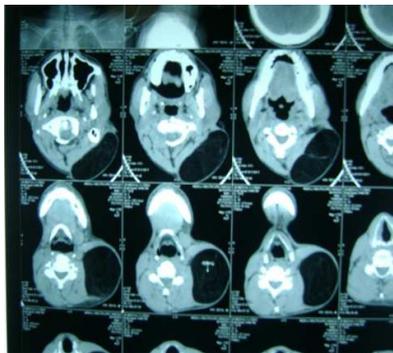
CT showing encapsulated mass measuring 11.3 cm superoinferiorly, 8.9 cm anteroposteriorly and 6.3cm transversely without infiltrating surrounding structure
